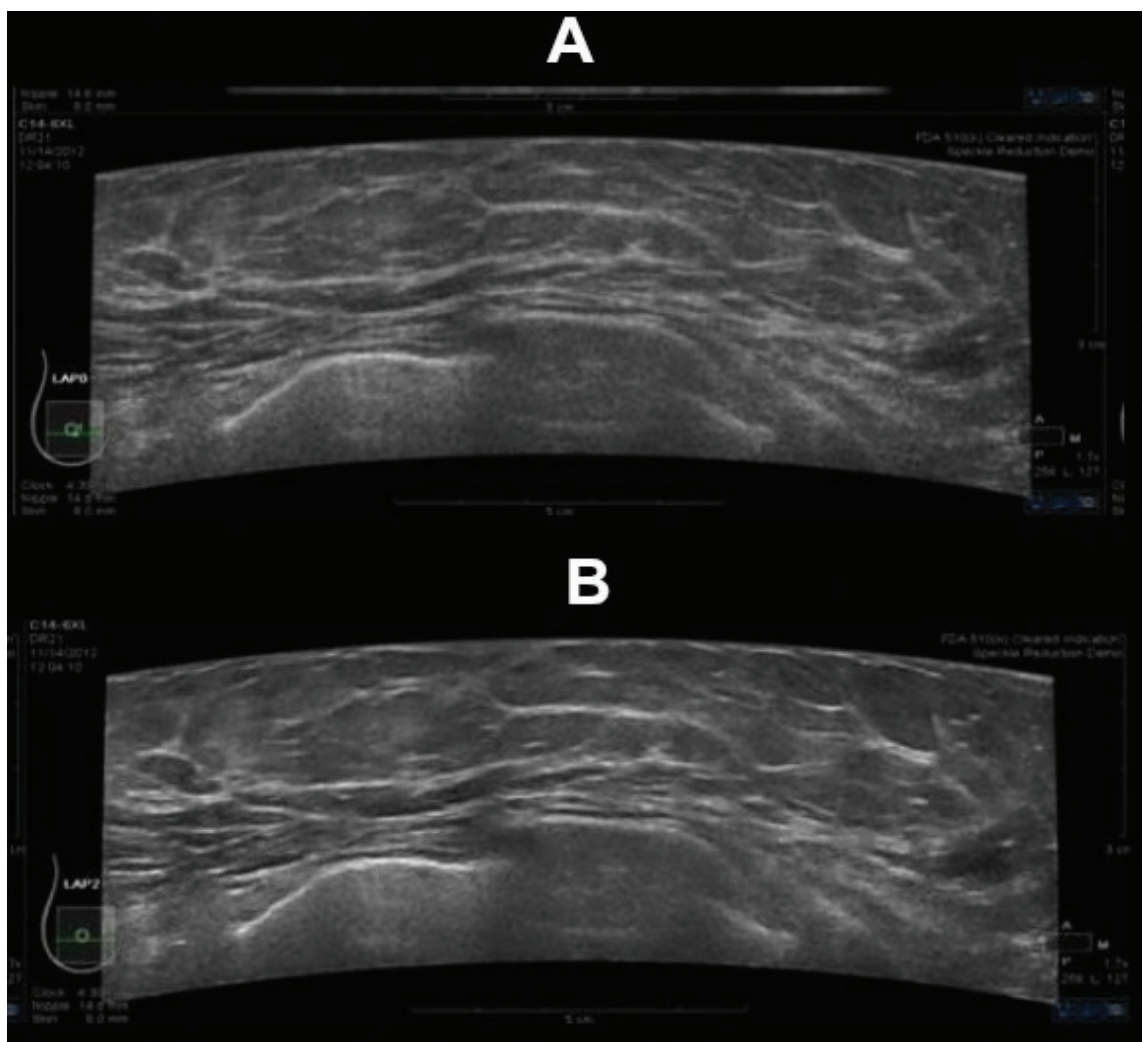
(A) Long axis view of transverse ultrasound demonstrating speckle artifact. Increased noise noted throughout the image and (B) long axis view of transverse ultrasound demonstrating speckle reduction.
